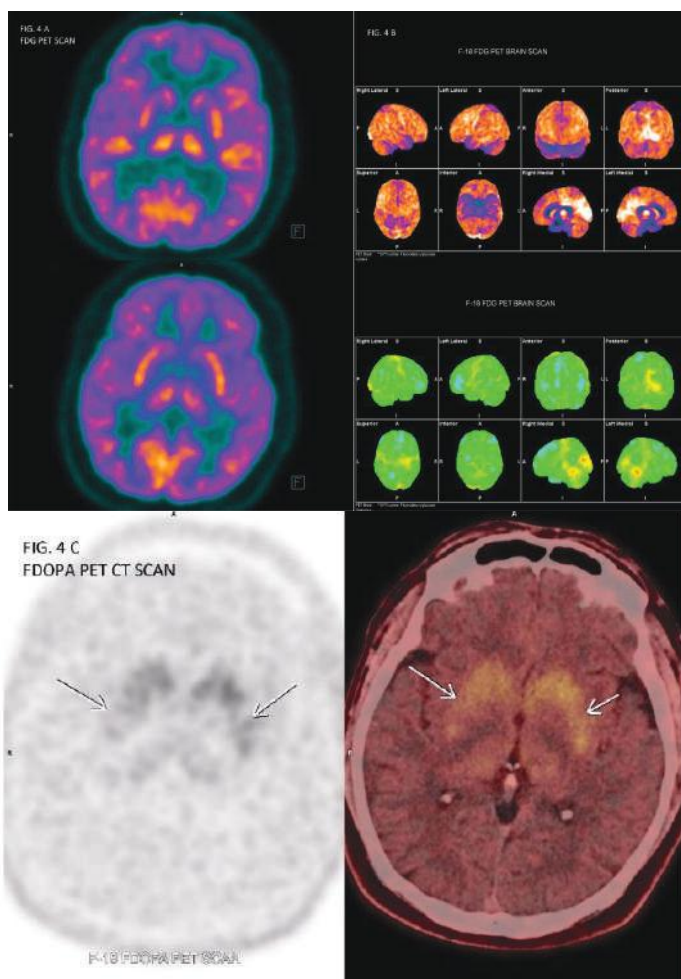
FFDG PET scan (Fig. 4a & b) demonstrates mild hypo metabolism in bilateral parietal and temporal cortices with preserved tracer uptake in bilateral basal ganglia. FDOPA PET scan (Fig. 4c) shows asymmetrically reduced FDOPA uptake in bilateral basal ganglia (right more than left) with putamen more severely affected than the caudate nucleus.
